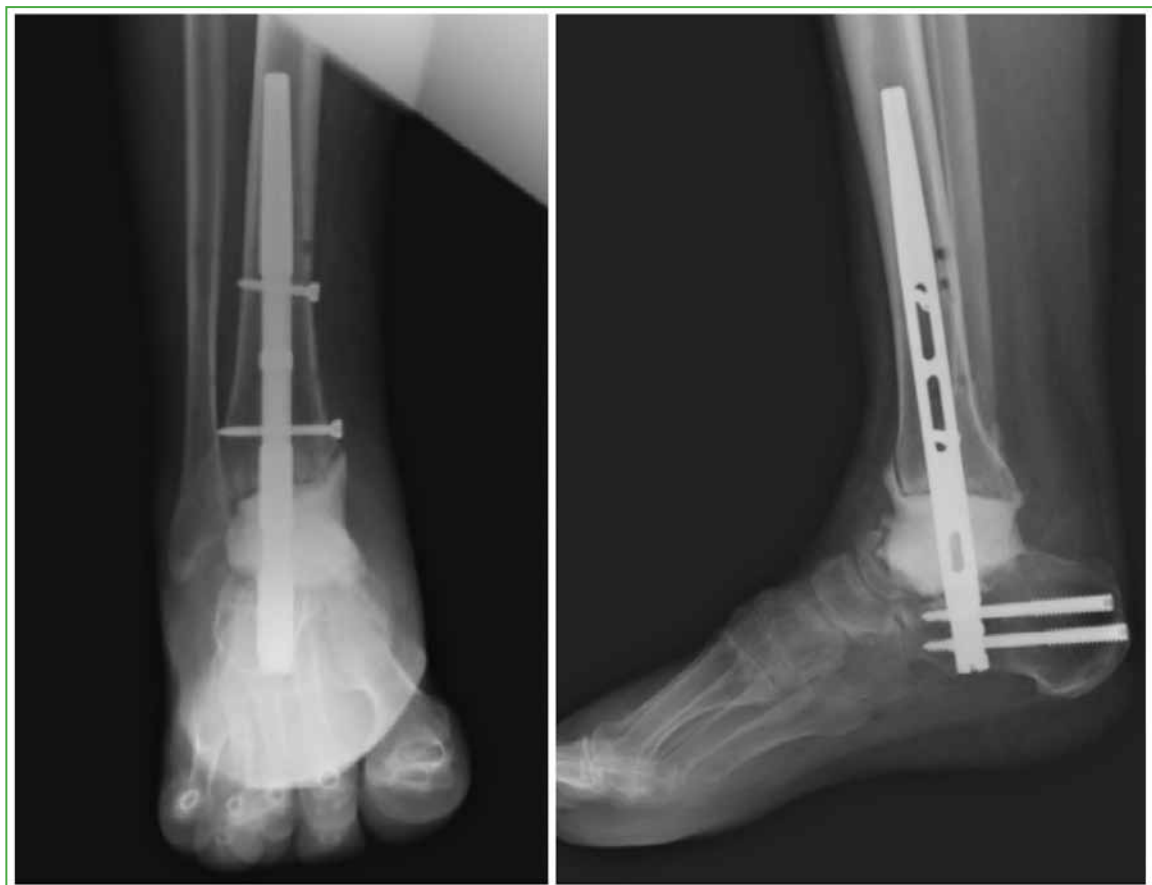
Anteroposterior and lateral ankle radiographs two months after the first surgery for pseudarthrosis of the talar neck plus necrosis of the talar body.
